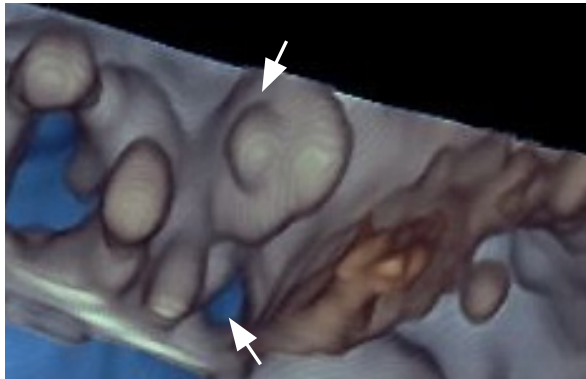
Transsthoracic echocardiography image after 3-dimensional reconstruction shows a right ventricular view. The PVL orifice is visualized located at 4 o'clock, close to the previously implanted VSD device.
